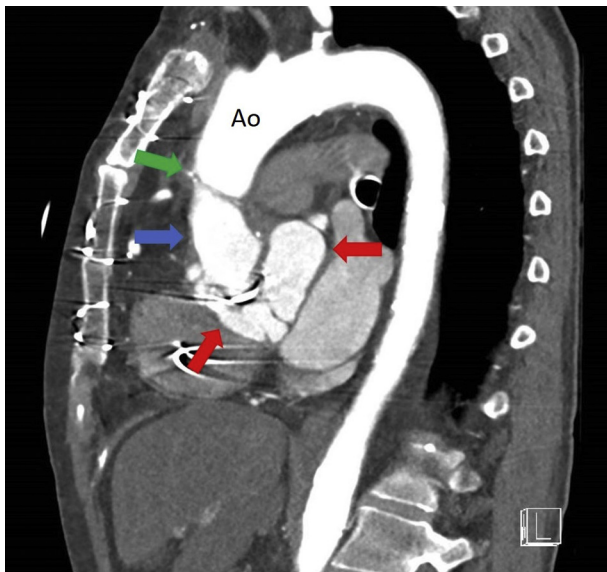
A sagittal slice from CTA showing the anterior and posterior extent of the pseudoaneurysm (red arrows) around the proximal ascending aorta prosthesis (blue arrow). The anastomosis between the prosthetic aortic root and the native aorta is visible (green arrow). Ao, Aorta.
